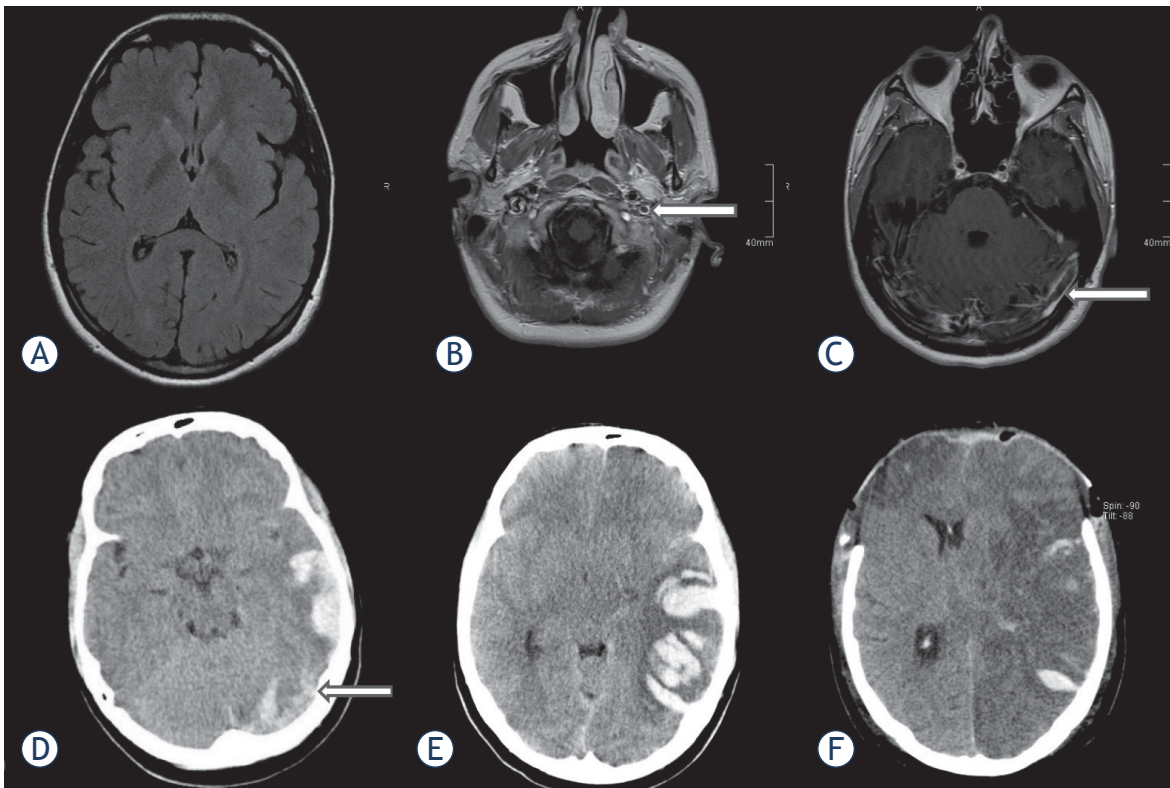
A 23-year old woman with headache followed by seizure and focal neurological deficit MRI on admission showed no focal lesions/oedema (A); contrast material-enhanced (CE) T1 and T2 showed occlusion of the left sigmoid sinus (B) and left transverse (C). Despite immediate anticoagulant treatment (fractionated heparin), the next day the patient became drowsy. CT revealed hemorrhagic infarction; in addition to the transverse sinus (arrow), the Labbe vein was suspected to be occluded due to the infarction territory (D). Decompressive craniotomy failed to prevent progression to irreversible coma (E,F).
